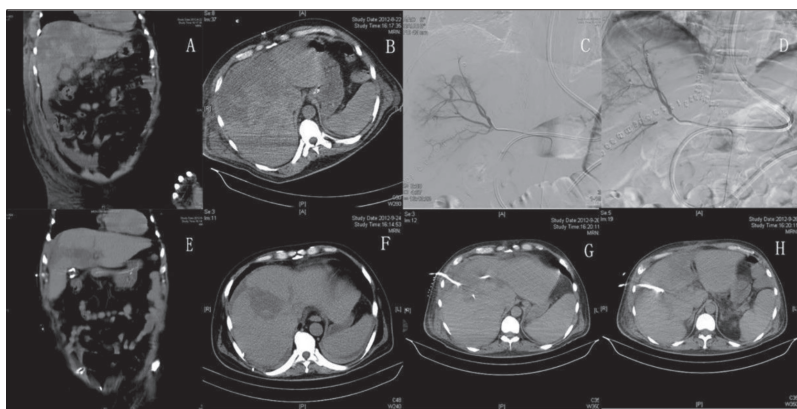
Case 1. A, B – a computed tomography (CT) scan of the abdomen taken 10 days after hepatorrhaphy; C, D – a hepatic arteriography showing active bleeding from the hepatic artery; the angioembolisation contributed to a lack of contrast extravasation from the artery; E, F – a CT scan of the abdomen taken 43 days after hepatorrhaphy, demonstrating that several abscess cavities and necrosis areas had formed in the liver; G, H – the abscess cavities were managed by percutaneous catheter drainage
